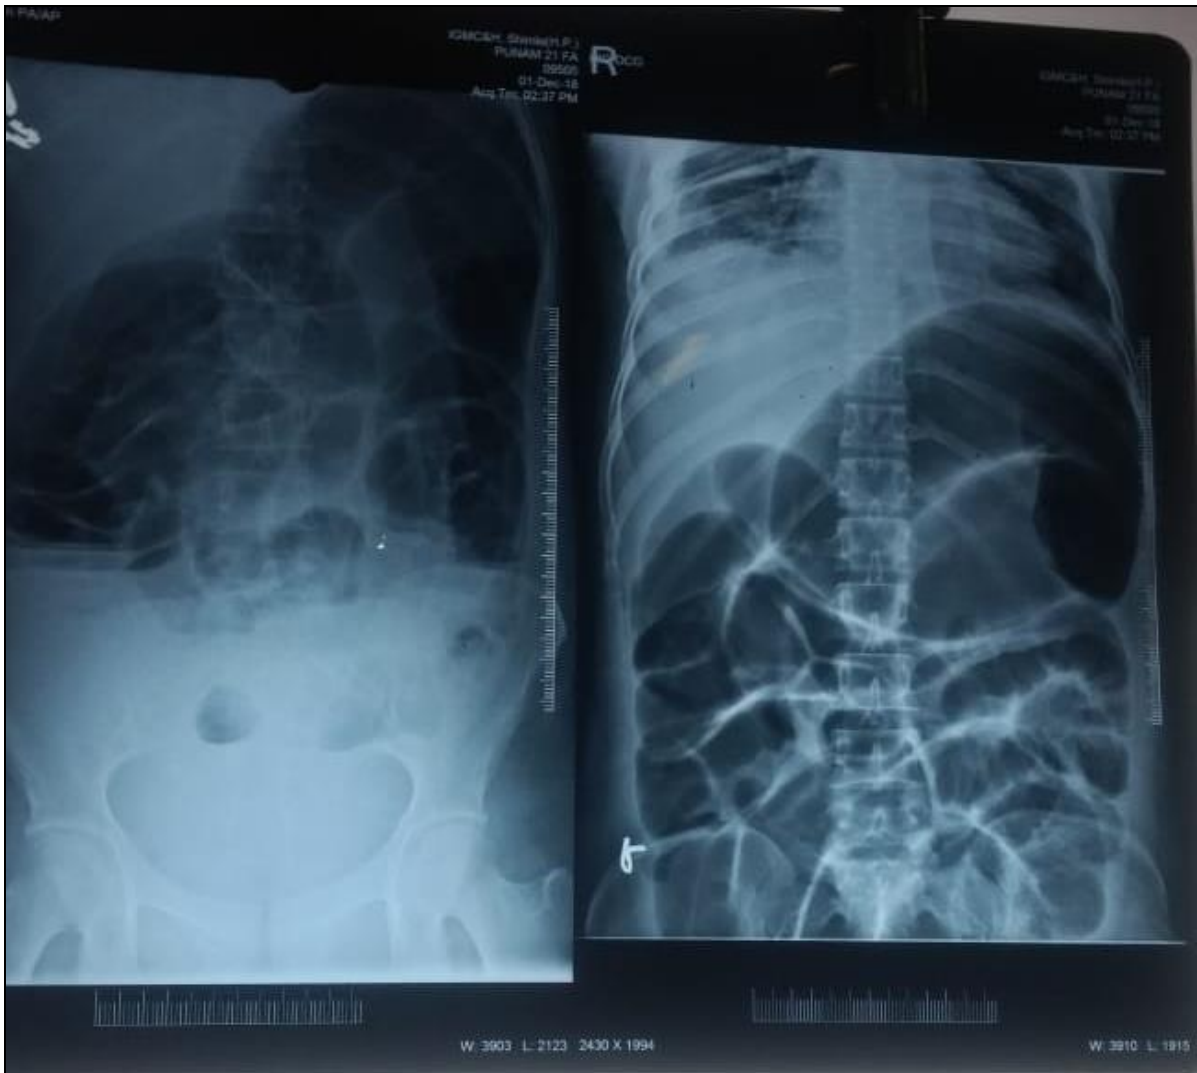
Abdominal Xray showing dilated small and large bowel loops.
